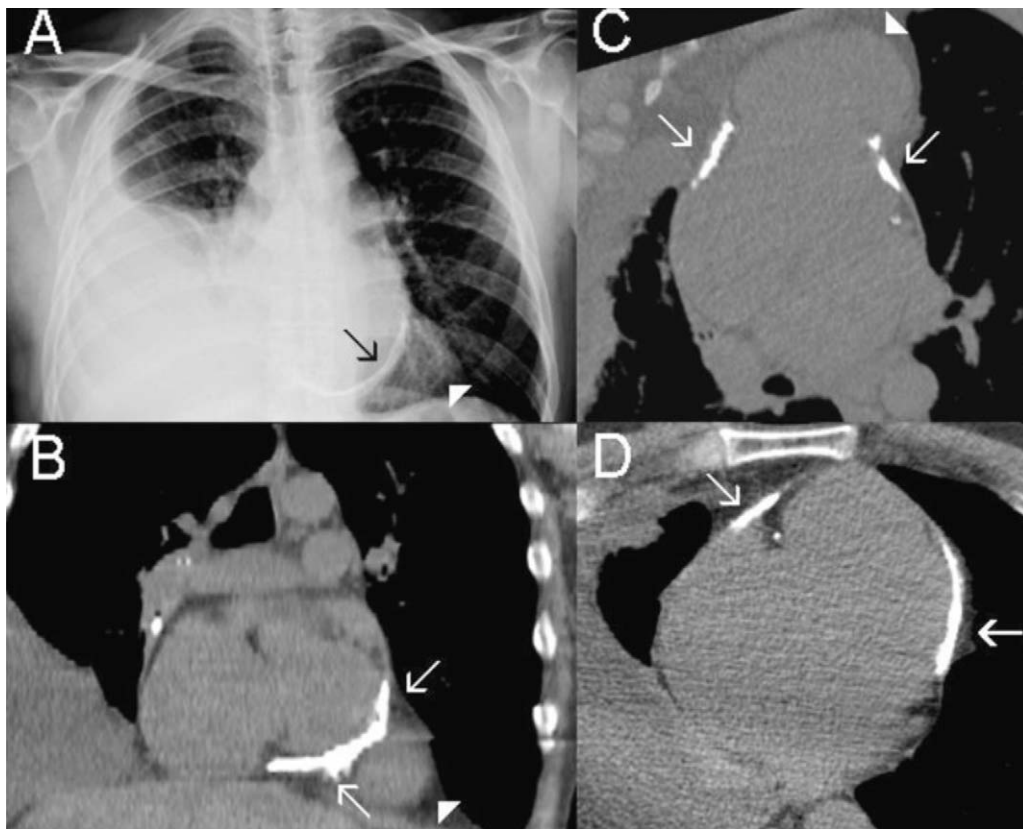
Chest X-ray (A) and computed tomography scans (B, C and D) showing pericardial calcifications (arrows) with spared ventricular apex (arrowed) and large right-side pleural effusion.
